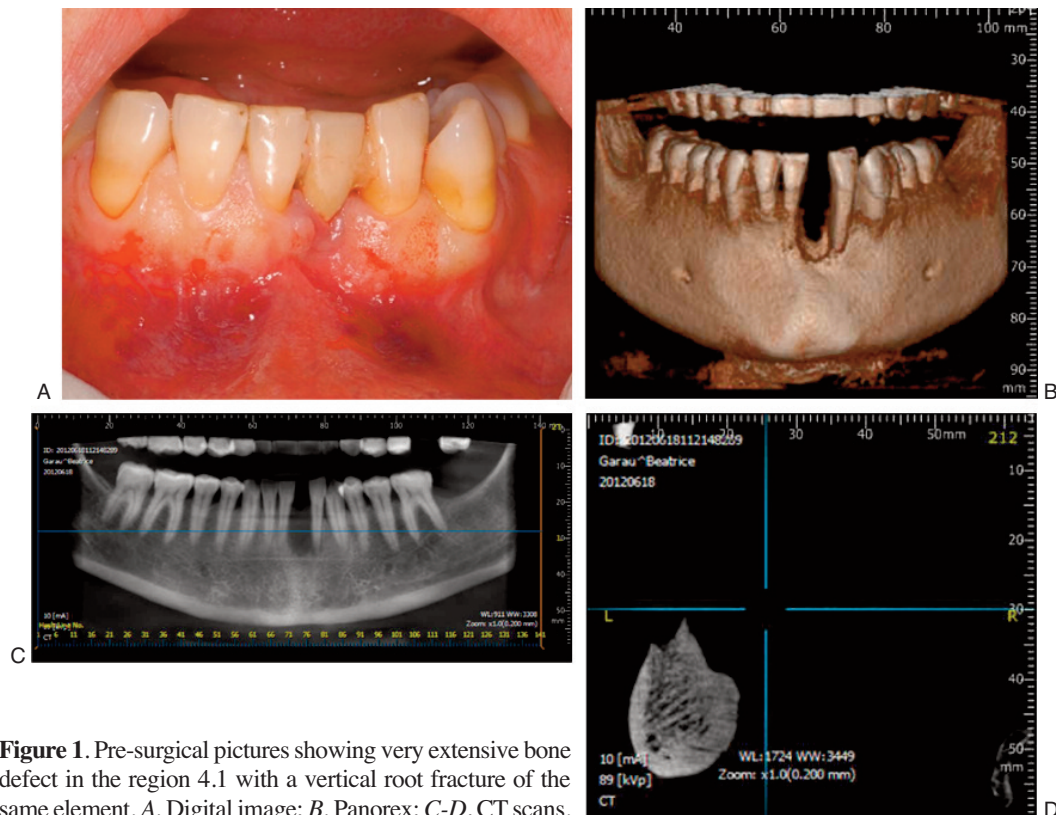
Pre-surgical pictures showing very extensive bone defect in the region 4.1 with a vertical root fracture of the same element. *A*, Digital image; *B*, Panorex; *C-D*, CT scans.
